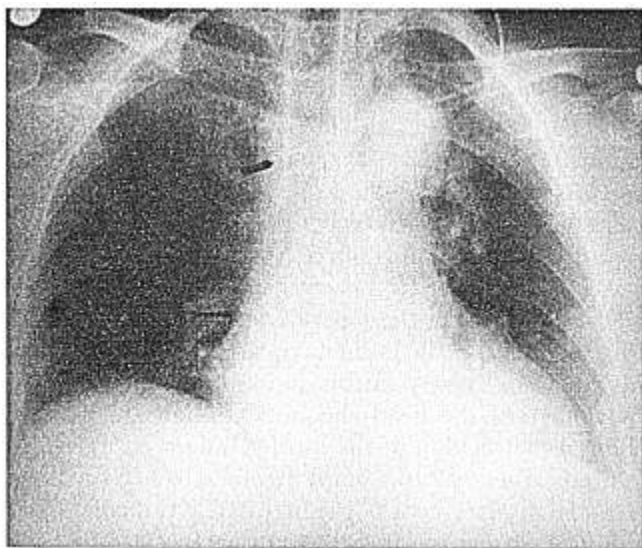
Chest roentgenogram showing the position of a 6-inch catheter inserted through the left external jugular vein. The arrow indicates the catheter's tip. The line marks the pericardial reflection. Notice that the terminal portion of the catheter lies in a transverse position, so that movements of the catheter cause it to push against the lateral wall of the superior vena cava.
